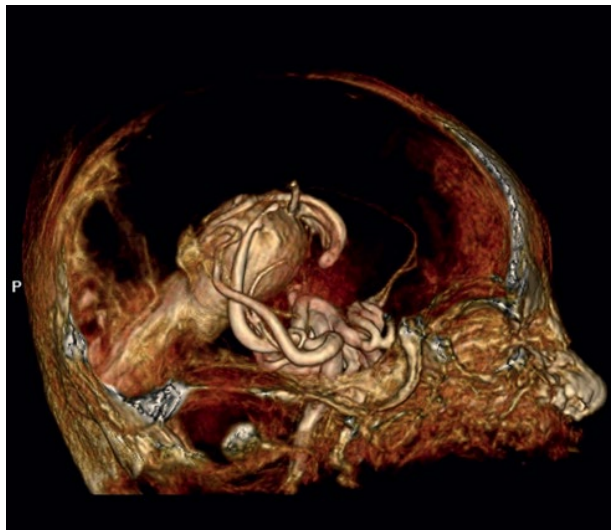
MRI angiography 3D reconstruction of a very large Vein of Galen aneurysmal malformation located in the pineal region with aneurysmal dilation. It receives blood predominantly from the vertebral arteries although some anterior supply is also suspected. Drainage is via the straight sinus to the torcula and bilaterally to the internal jugular veins. *Source:* Courtesy of A. Prof Frank Gaillard, Radiopaedia.org, rID: 22778.
